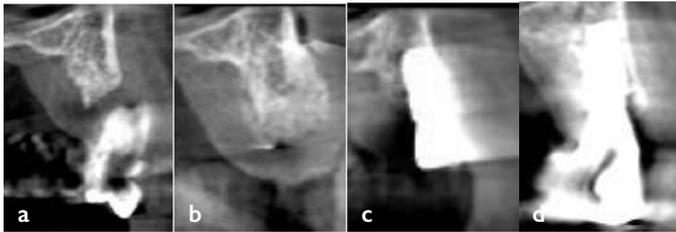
CT scans taken before extraction of tooth #24, after socket preservation, after implant placement, and after completing the final restoration, respectively
